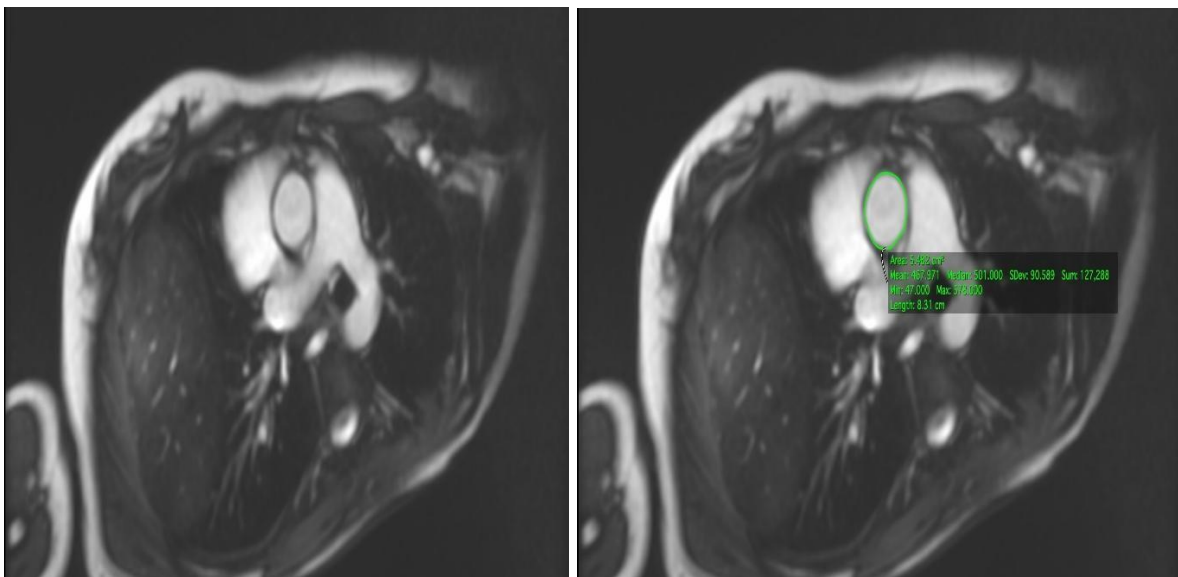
(left): cardiac MRI axial image of the ascending aorta during systole and figure 1a (right): traced aortic circumference to obtain area and calculate aortic distensibility.
